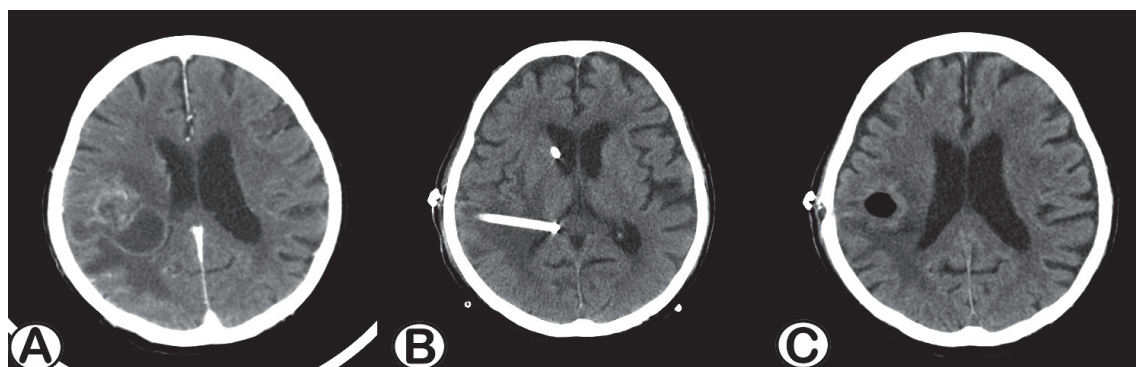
Serial brain CT of the patient. (A) Day 148, contrast-enhanced brain CT showing a lobulated marginally-enhancing cystic mass lesion with perifocal edema at the right temporo-parietal lobes, leading to compression of the right lateral ventricle, (B) Day 156, non-contrast brain CT showing placement of an external ventricular drain into the right lateral ventricle, (C) Day 162, non-contrast brain CT showing the presence of pneumocephalus after removal of the external ventricular drain and resolution of the brain abscess.
